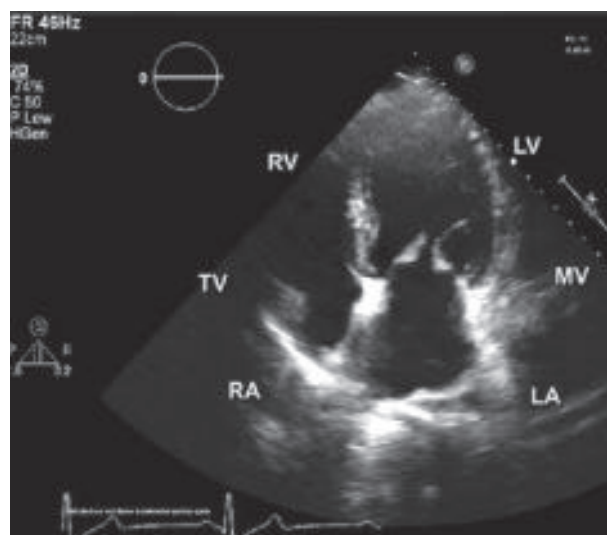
Two- dimensional transthoracic echocardiograms. Show a thickened MV valve.
